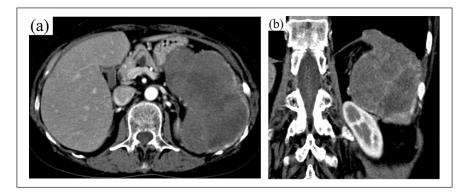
Contrast-enhanced computed tomography showing a lobulated hypodense mass in the spleen: (a) transaxial image; (b) coronal image.
